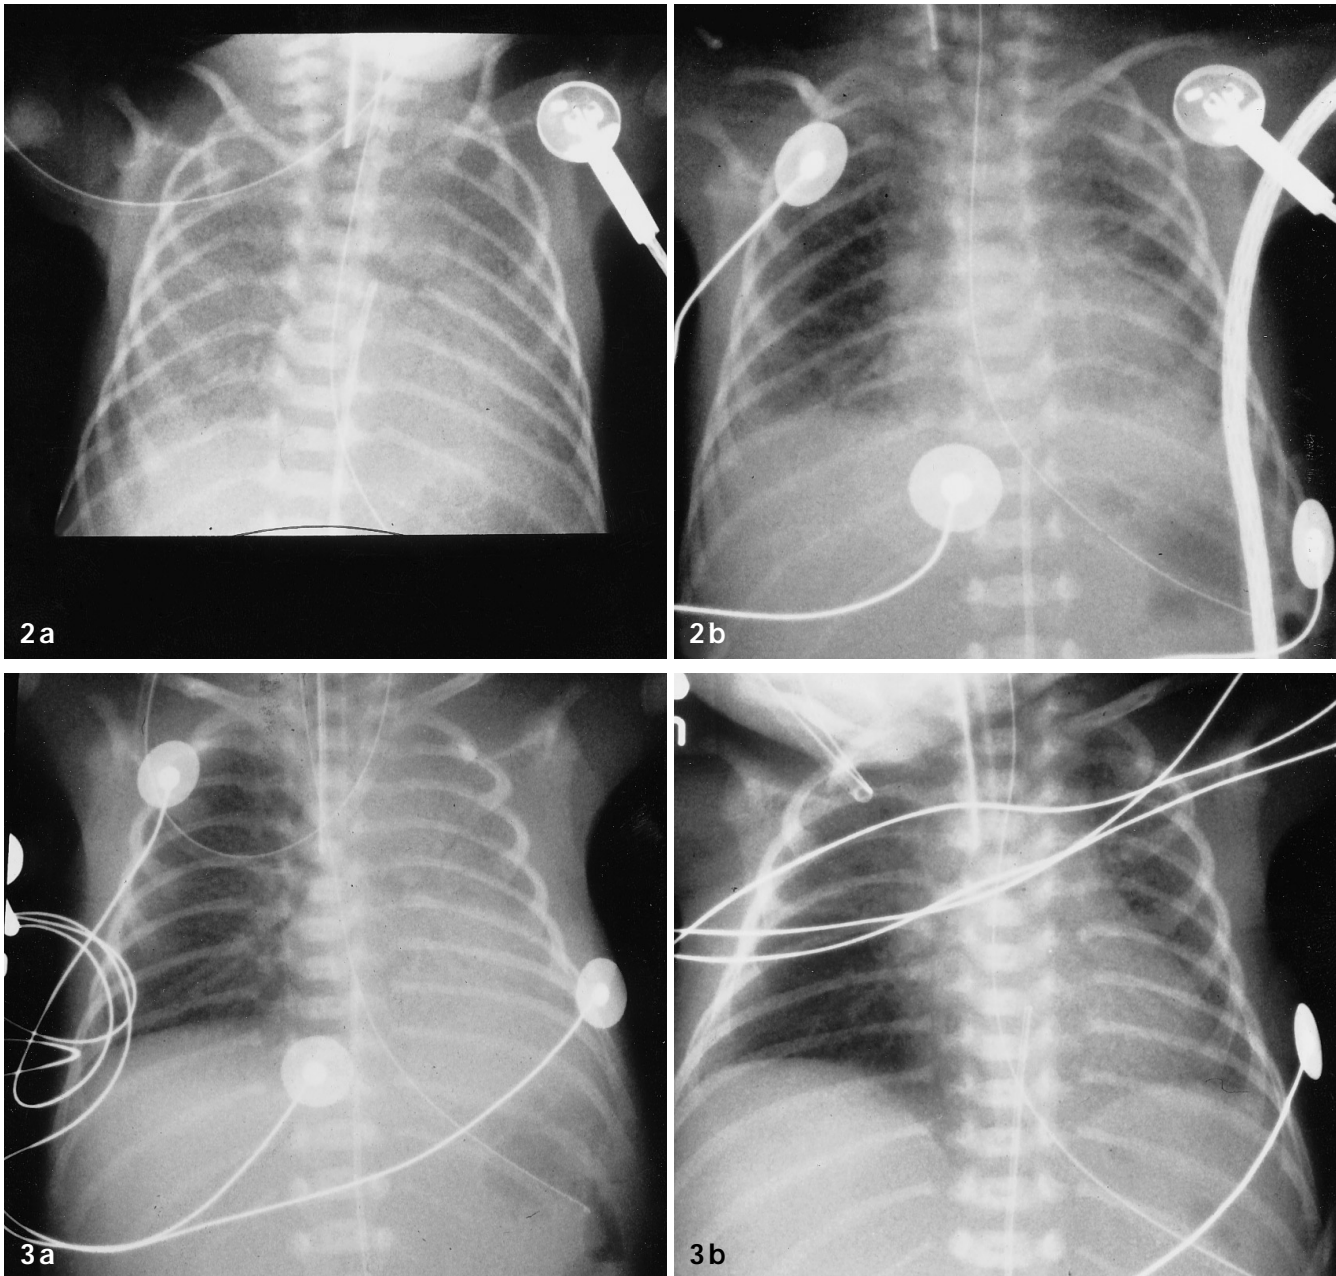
a, b Preterm infant (GA 28 weeks, 920 g) with severe RDS: chest radiographs with typical severe RDS a before and b after surfactant treatment. Clearing is more pronounced in the central regions
